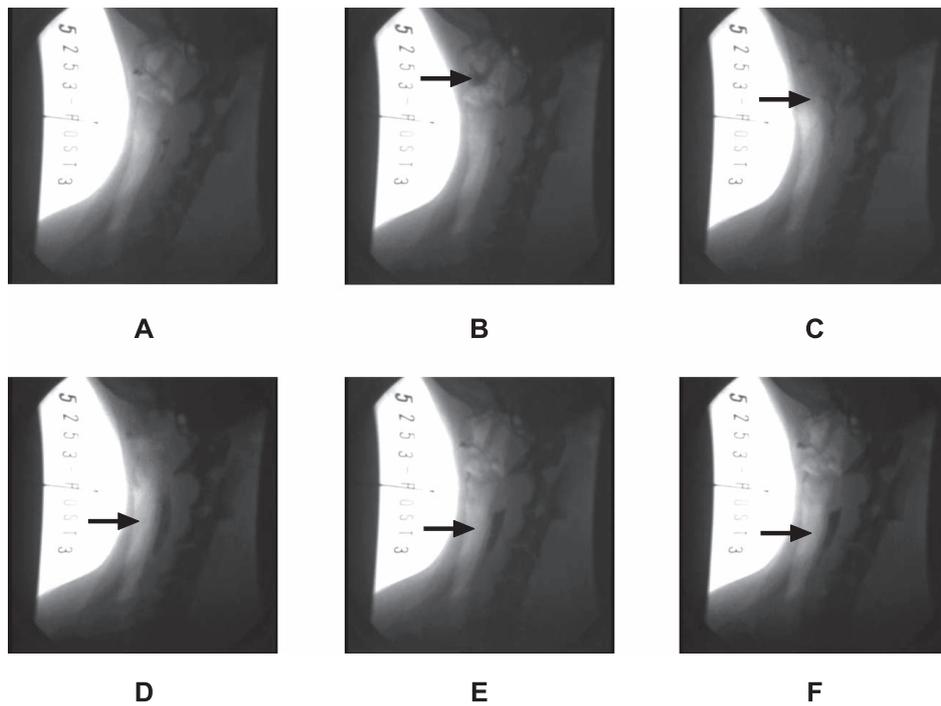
Typical X-ray images of marker congestion in the upper esophagus. The experimental method is the same as that in Fig. 1. A, B, C: Images are the same as those in Fig. 1. D, E, F: Images are different from those in Fig. 1. The marker does not pass completely through the esophagus but stops in the upper esophagus.
